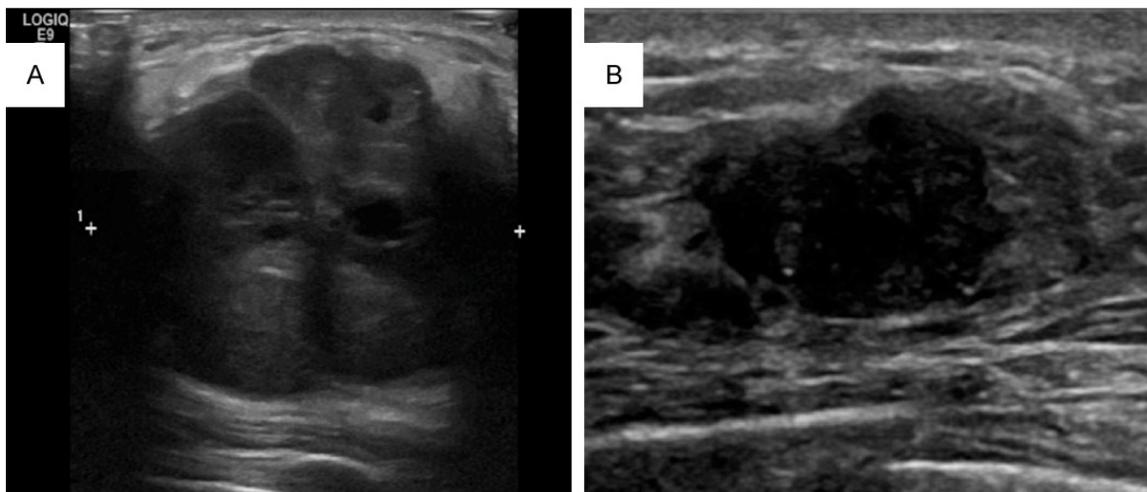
A: The inside ultrasonic performances of the BRCA1 mutation-associated lesions tend to appear with liquefaction necrosis, and preform as mixed echo; B: The inside ultrasonic performances of the breast cancer without BRCA1 mutation tend to appear with hypochoic or no liquefaction necrosis.
